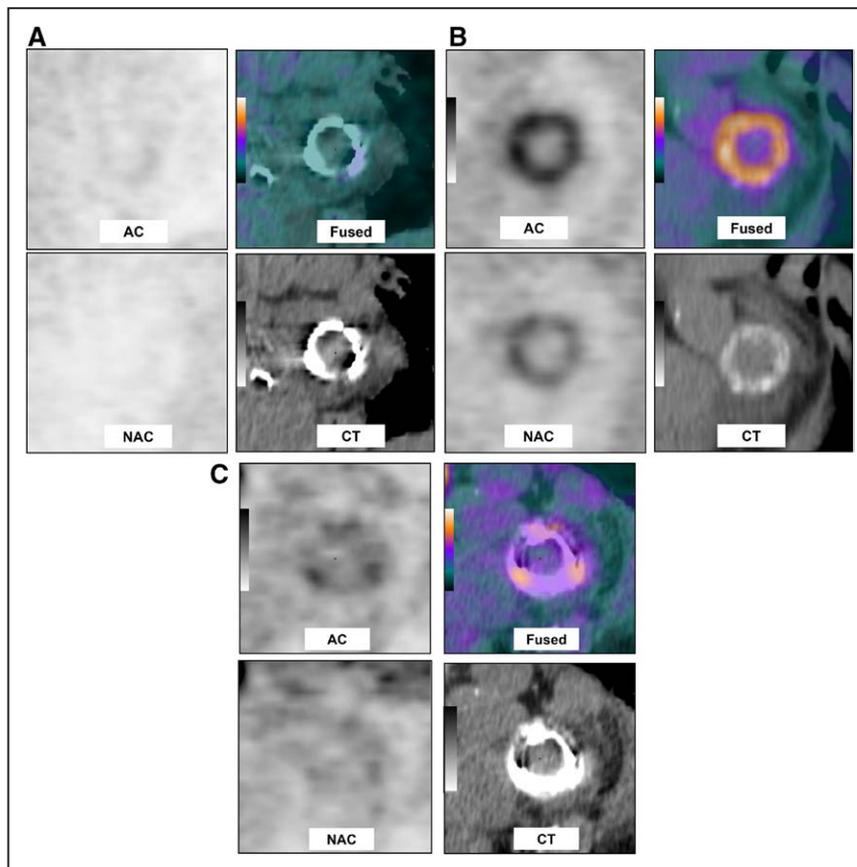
Examples of ¹⁸F-FDG perivalvular uptake in noninfected patients. Reoriented (oblique) views in the plane of valve showing (A) absence of uptake in a 38-year-old woman with a biological prosthetic heart valve (PHV) implanted 3 years before for the indication of IE, who underwent FDG PET/CT in the work-up of lung cancer; (B) intense and homogeneous uptake in a 58-year-old woman with a biological PHV implanted 8 years before for the indication of aortic regurgitation because of infective endocarditis; (C) heterogeneous uptake in an 83-year-old female implanted with a biological PHV for severe mitral regurgitation 5 weeks before undergoing FGD PET/CT in the setting of fever with increased C-reactive protein level (48 mg/L). After 6-month follow-up without antibiotic therapy, no event occurred. The focal enhancement of the FDG uptake corresponds to the metallic stent posts of the valve. AC indicates attenuation-corrected images; CT, computed tomography; IE, infective endocarditis; NAC, non attenuation-corrected images; and PET, positron emission tomography.
